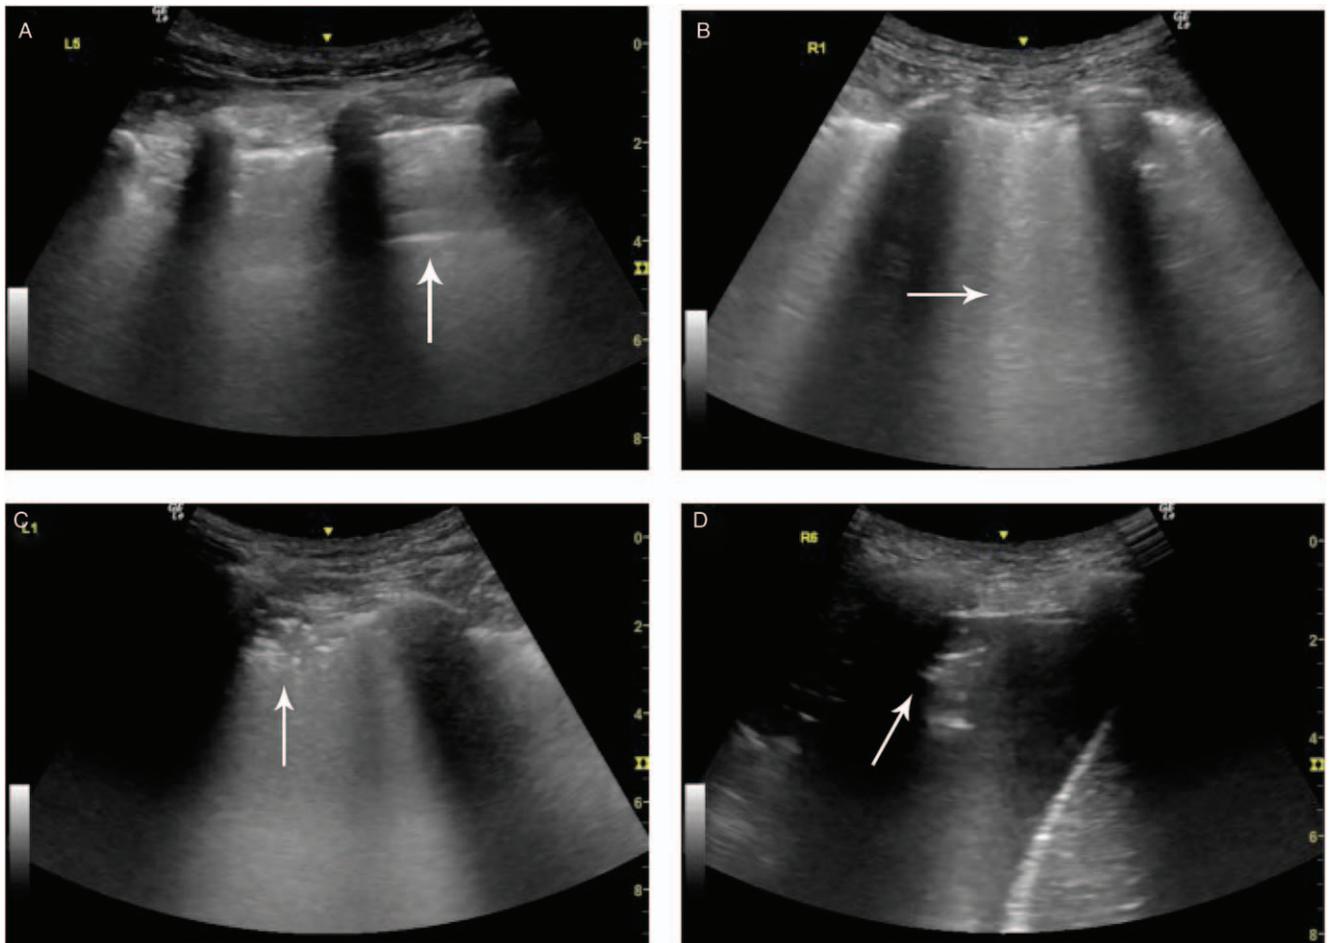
Four characteristic ultrasound findings of COVID-19 pneumonia: (A) thickening of the pleural line with A lines. (B) Confluent B lines. (C) Multifocal small consolidations. (D) Consolidations and pleural effusions.
